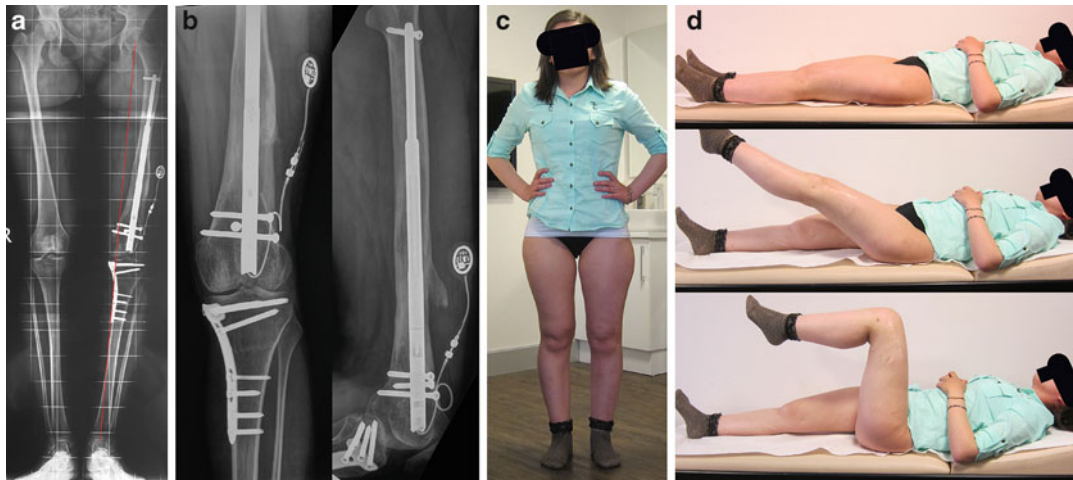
(a, b) LSR and standard X-rays at 1 year postsurgery. MAD is medial but clinical appearance is normal with equalization of leg lengths. (c, d) Clinical photos of function after treatment. Note full knee extension but some loss of flexion
